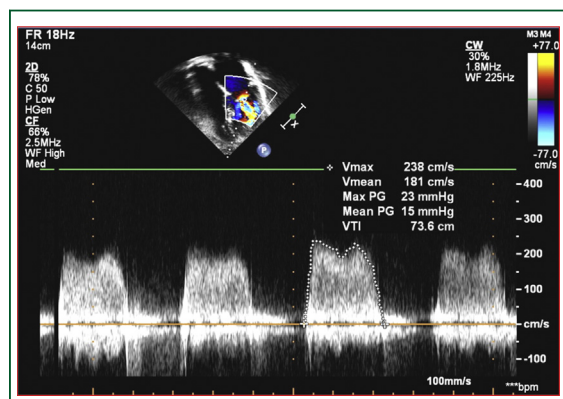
Maximum and mean gradients across mitral valve as seen on Doppler signal across mitral valve in a patient with mitral stenosis.
